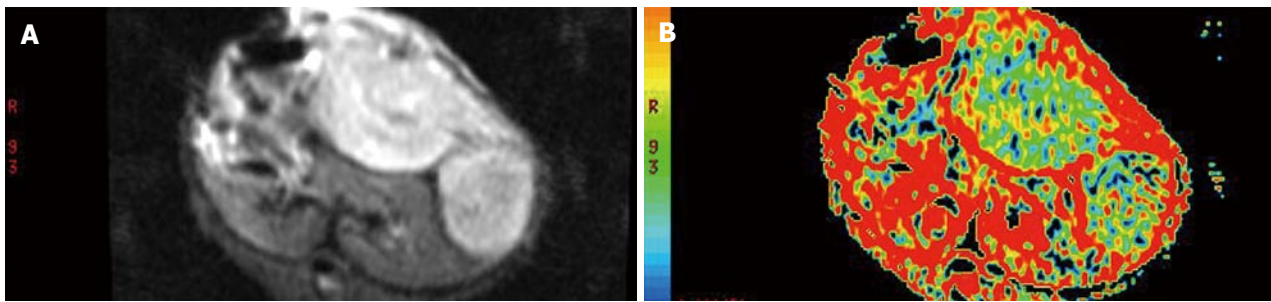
Image manifestations of hepatic VX-2 tumor on DWI and ADC map when b-value was 100 s/mm² at 6 h after chemoembolization A: High signal and distinct margin of VX-2 tumor on DWI; B: Low signal of it on the ADC map.
